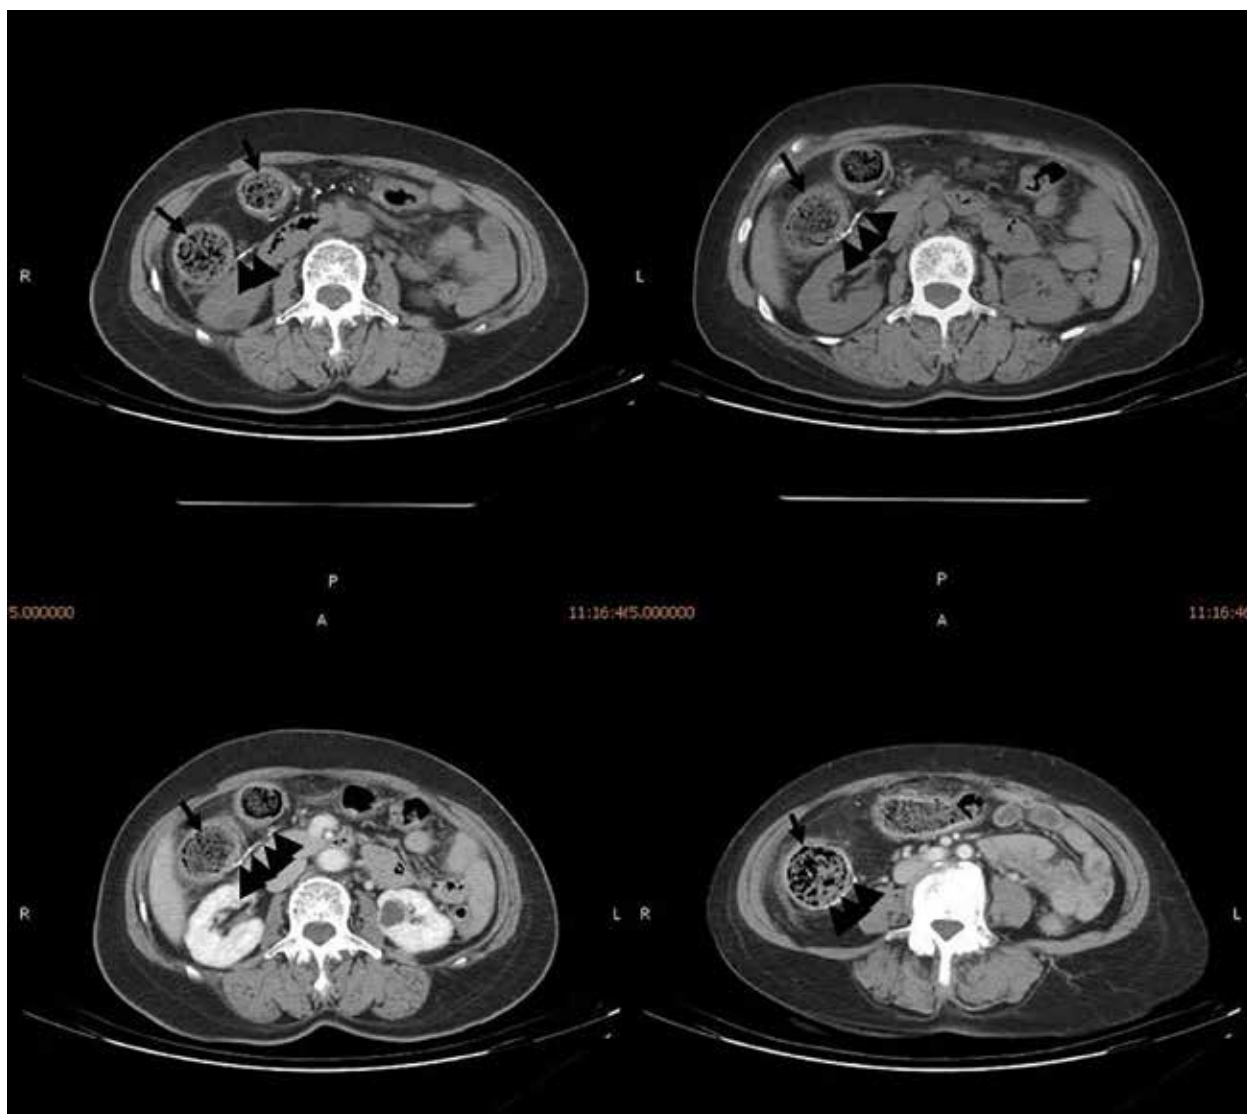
Image of abdomen CT; the images revealed thread-like calcifications along the colonic vessels (arrowheads), edematous thickening of the colonic wall from the terminal ileum to the hepatic flexure (arrow)
